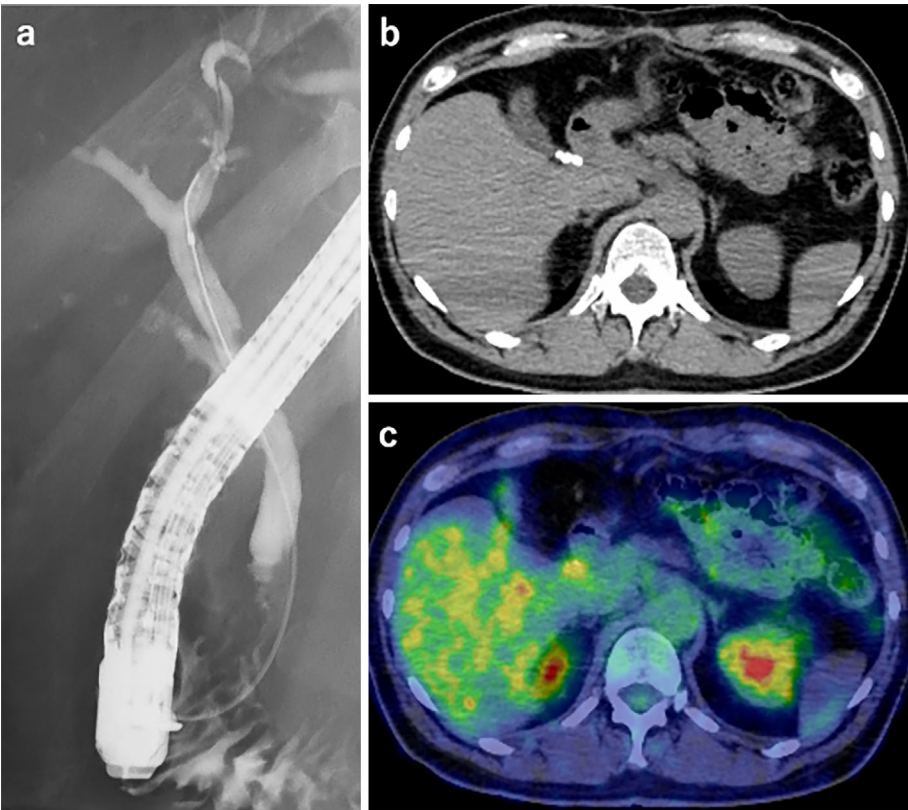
ERCP (April, 20XX+1) and PET-CT (December, 20XX+1) findings. Stenosis of the common bile duct and the soft tissue mass around the celiac artery had improved (a. ERCP, b. plain CT, c. PET-CT).
